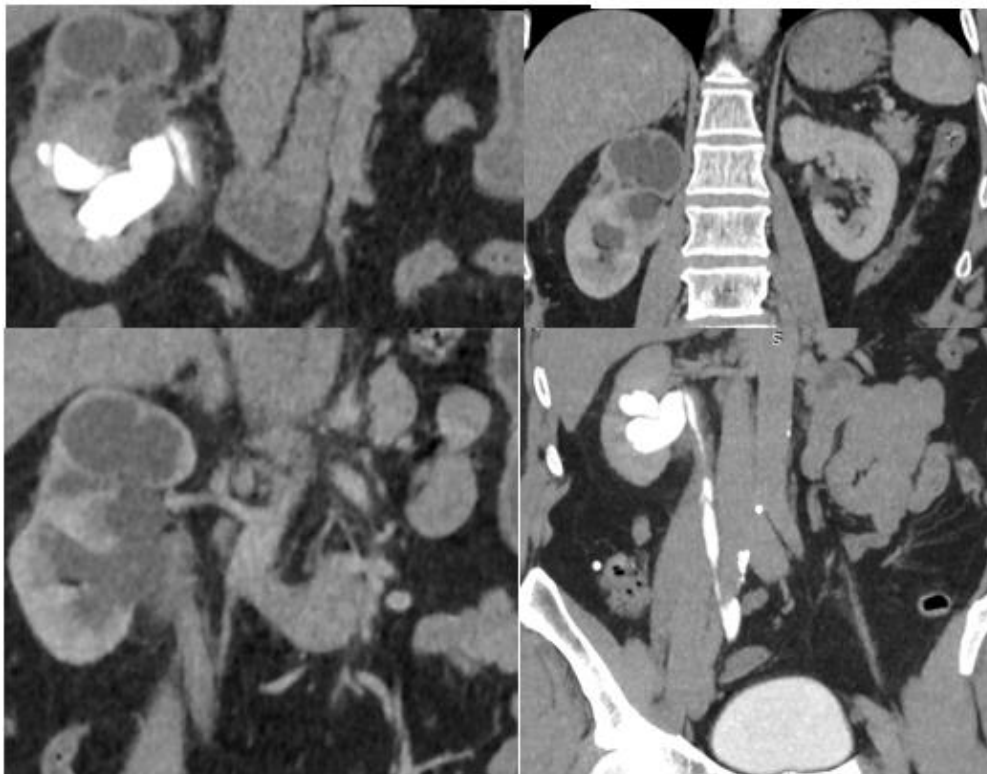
CT urography findings of right hydronephrosis associated with circumferential thickening of the renal pelvis and ureteral wall
